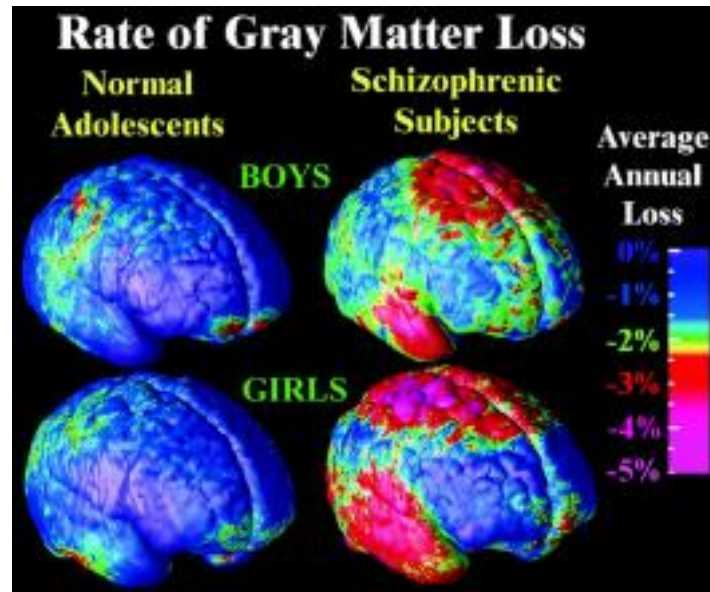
Magnetic Resonance Image (MRI) showing grey matter loss in the frontal, parietal, and temporal regions of the brain in both males and females diagnosed with EOS. (Thompson et al., 2001)
